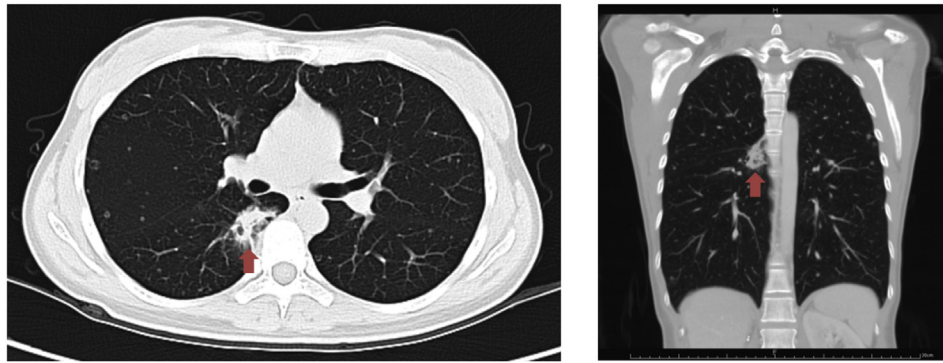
Computed tomography of the chest revealed an irregular mixed soft-tissue cystic lesion measuring approximately 3.2 cm in the superior right lower lobe (arrow) and multiple cavity or cystic lesions with thick walls in all lobes of both lungs, which raised suspicion of lung metastases.
